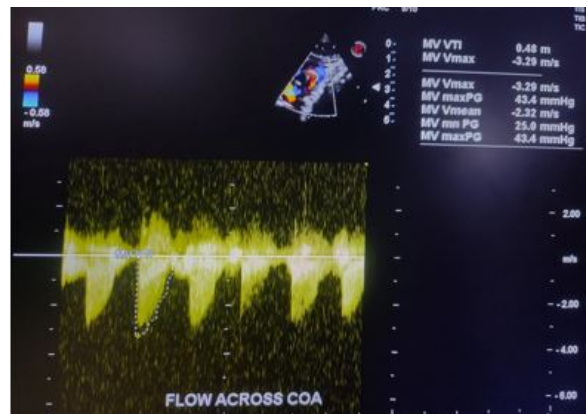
CW Doppler flow across COA is indicative of a peak/ mean gradient of 43.5/25 mm hg, consistent with moderate COA
